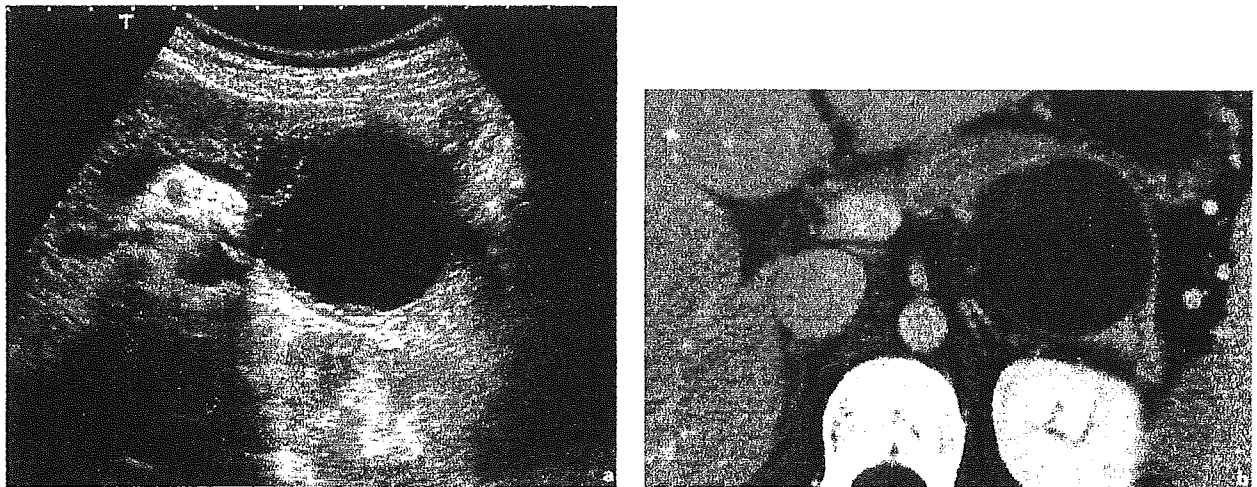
Ultrasonogram (a) and computed tomogram (b) demonstrating an MCN.
